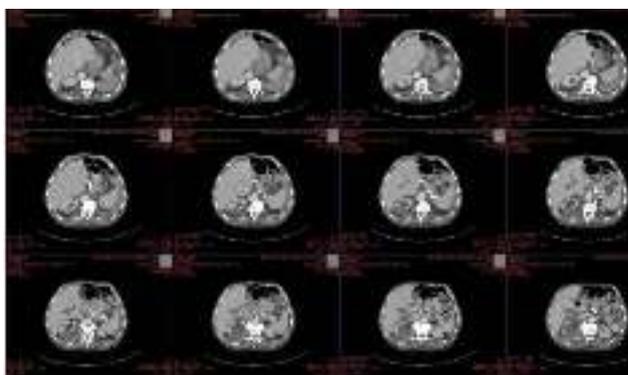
abdomen CT of the patient
